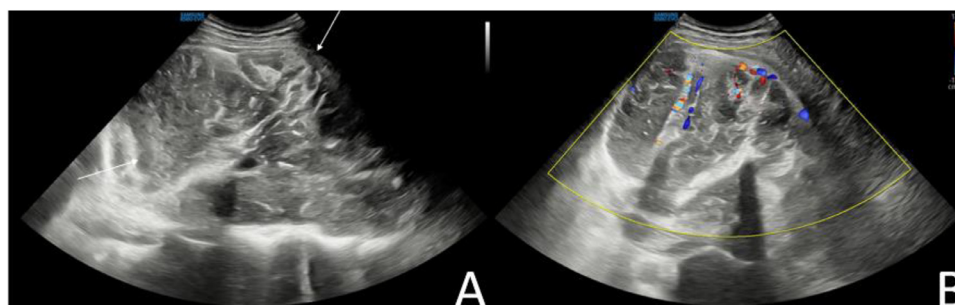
US images show a large heterogenous soft tissue mass (A, white arrow). Doppler images show tumor vascularity (B).
